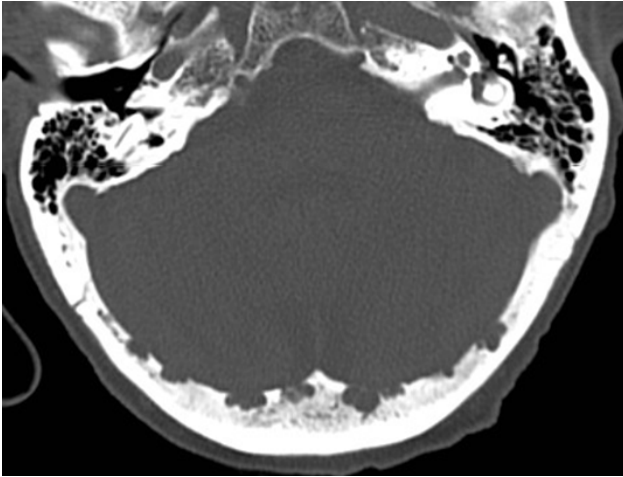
Skull CT, bone window. Typical Pacchioni granulation aspect placed at lateral sinuses level.
